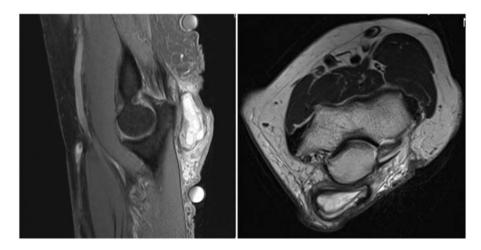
Magnetic resonance images of enhancing olecranon bursitis.
